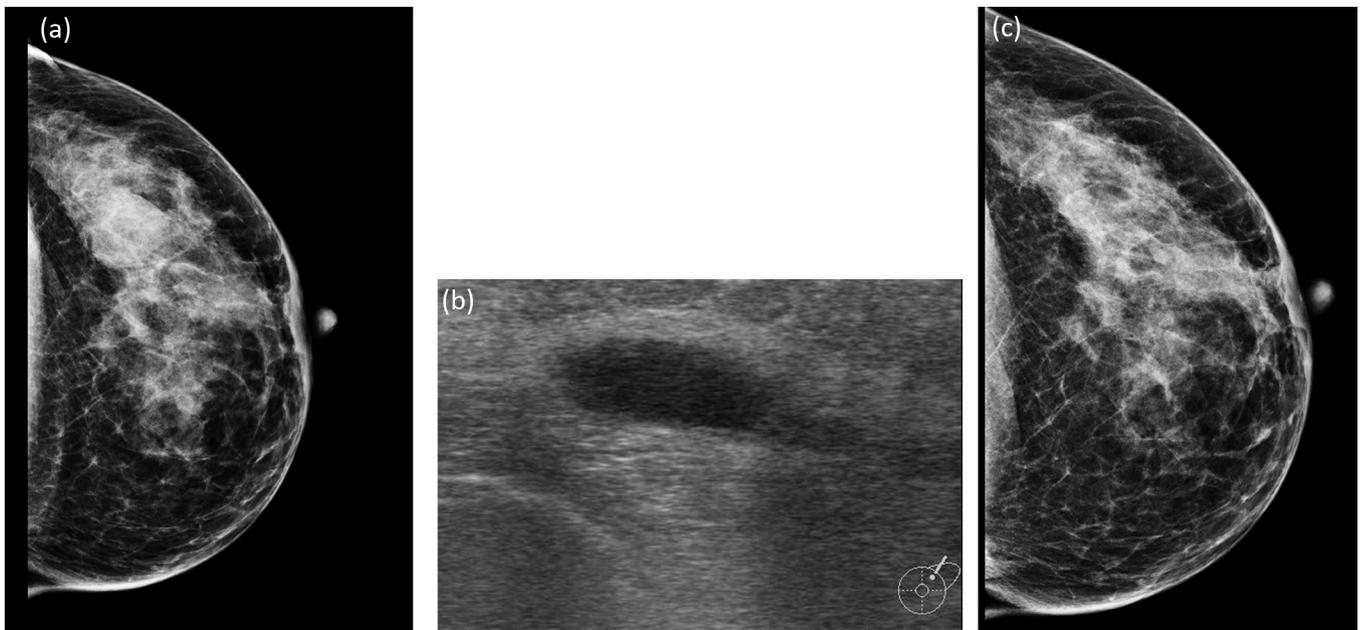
Example of downstaging to BI-RADS category 1 or 2. Fifty-year-old woman was referred with a positive screening mammogram. Craniocaudal mammographic view (A) showed a low-density radiopaque, oval lesion with partly ill-defined border in the left breast. Ultrasonography (B) showed a oval lesion with posterior acoustic enhancement and a sharply defined border in keeping with a simple cyst. Cyst aspiration was performed under ultrasound guidance. Repeated craniocaudal mammographic view (C) after cyst aspiration proved that the detected lesion on the screening mammogram was caused by a cyst and had disappeared after cyst aspiration.
